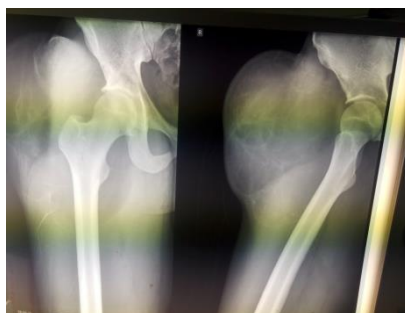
Xray shows the extents of the tumour
